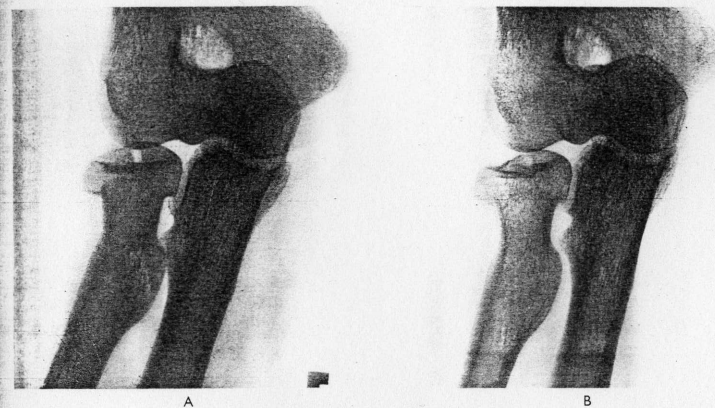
Case E. W. A, The original anteroposterior radiograph. The fracture of the head of the radius had been considered a 'borderline' case and treated conservatively. The fracture involves more than one-quarter of the articular plateau and it tilted out of line. B, The subsequent radiograph taken 27 months later. The fracture has united, leaving a grossly distorted radial head. Note the fissure still present in the articular plateau. This patient had lost 60° of rotation range of the elbow-joint and was now undertaking lighter work.
